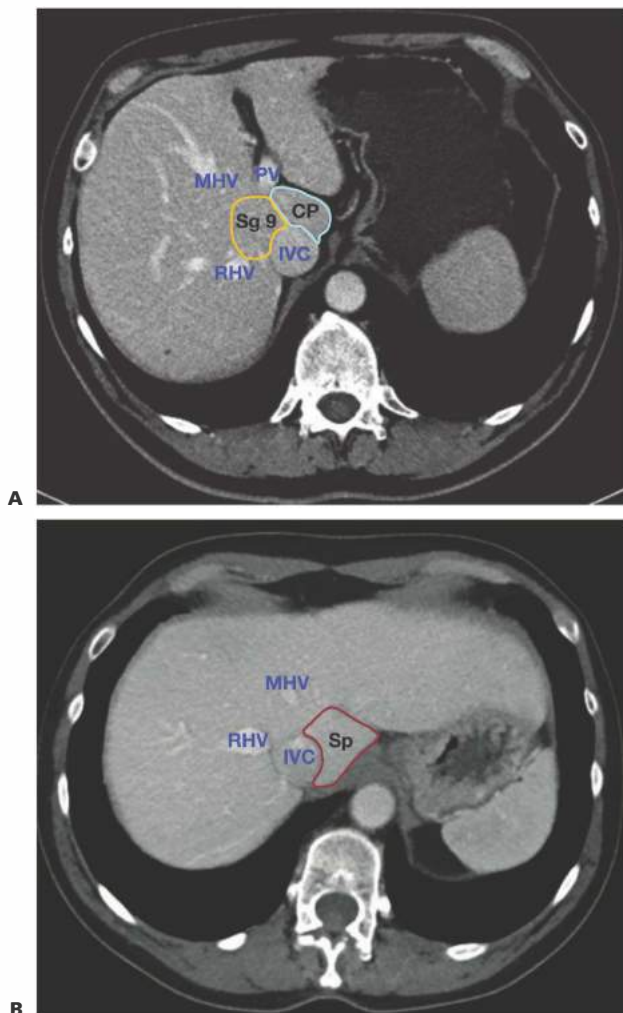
• A. Axial CT image showing the caudate lobe. The caudate process (CP) is bounded by the anterolateral surface of the IVC, the left portion of liver hilum, and the left hepatic vein (not shown). Segment 9 (Sg 9) is known as the paracaval process and is bounded by the anterior surface of the IVC, the middle hepatic vein (MHV), and the right hepatic vein (RHV). Also shown is the portal vein (PV). B. Axial CT image (slightly more caudal than in [A]) showing Spiegel's lobe (Sp)—also known as segment 1—as it wraps around the medial aspect of the IVC.
